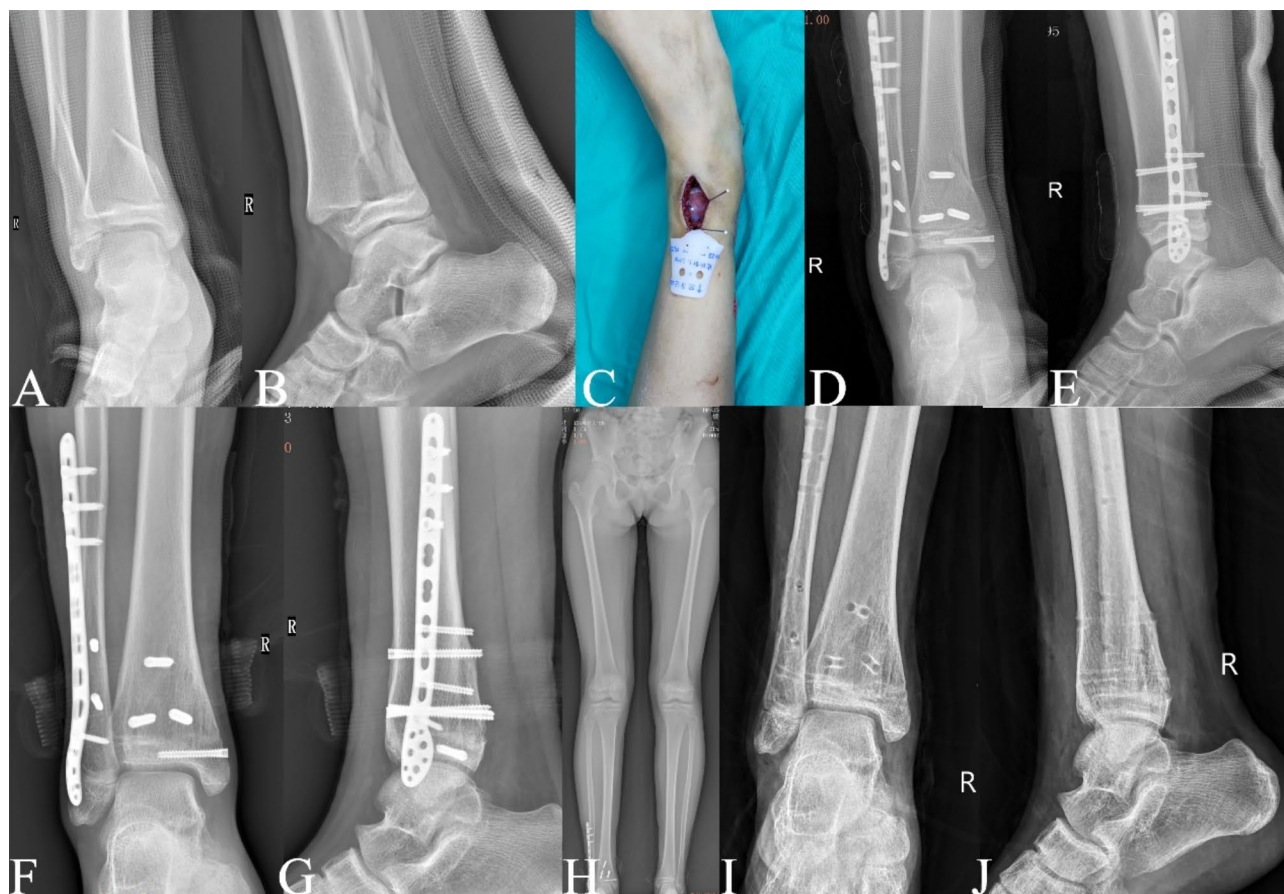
Case example: a girl, fell from her bike. A and B, Anteroposterior and lateral radiographs demonstrating a tibial epiphyseal fracture on the right side (Salter–Harris IV). C, Construction and application of a 3D printing template intraoperatively. D and E, Radiographs taken postoperatively. F, G and H, Radiographs taken after 12 months of follow-up. I and J, Radiographs taken after removal of hardware
